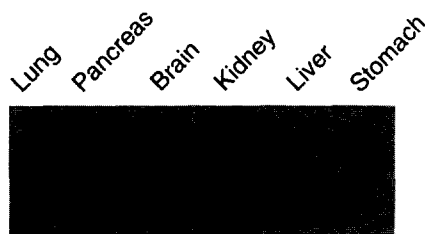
RNase protection assay. A riboprobe synthesized from the human pancreatic GLP-I receptor cDNA was hybridized with total RNA (60  $\mu$ g) isolated from human lung, pancreas, brain, kidney, stomach and liver. The molecular size of the RNA:RNA hybrids was determined by gel electrophoresis and visualized by autoradiography after exposure to an X-ray film for 21 days.
